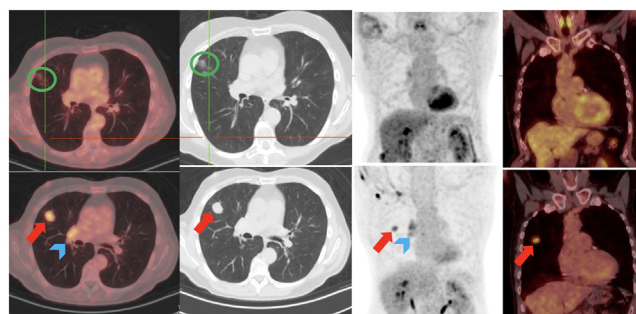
74-year-old diagnosed with small cell lung cancer on biopsy of right lung mass. Comparison of [^{18}F]FDG PET/CT images at Baseline (bottom row) and end-of-therapy (top row). Baseline [^{18}F]FDG PET/CT imaging (bottom row) showed avid mass in right lung (red arrow) and an ipsilateral active hilar node (blue arrow-head). After completion of chemo-radiation, [^{18}F]FDG PET/CT imaging (top row) was done to assess therapy response. No evidence of FDG avid neoplastic disease. Previously seen right lung primary tumour is now a scar (green circle). Previous hilar node now calcified and inert. Overall findings was consistent with complete metabolic response.
